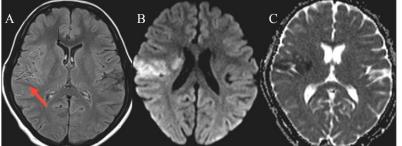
A- FLAIR images showing slow flow in right MCA branches in the sylvian fissure (arrow). Fig 6.B. DWI imaging showing wedge shaped infarct and Fig 6.C: ADC image showing hypointensity in the same region.
